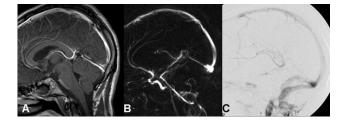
(A) Sagittal T1-weighted magnetic resonance imaging at repetition time (TR) = 500 and echo time (TE) = 17 after intravenous administration of gadolinium (III) diethyltriaminepentaacetic acid shows the thrombus in the straight sinus near the confluence of the great cerebral vein of Galen and the inferior sagittal sinus, surrounded by a narrow trace of contrast media. (B) Some blood flow around the thrombus leading to an incomplete occlusion can be detected in phase contrast magnetic resonance angiography at TR = 86 and TE = 10, which is part of the routine protocol for cerebral sinus thrombosis. (C) Retention of contrast media in the great cerebral vein of Galen, the internal cerebral veins, and the thalamostriate veins can be clearly demonstrated in the venous phase of conventional angiography, proving the hemodynamic relevance of the occlusion for development of thalamic edema.
